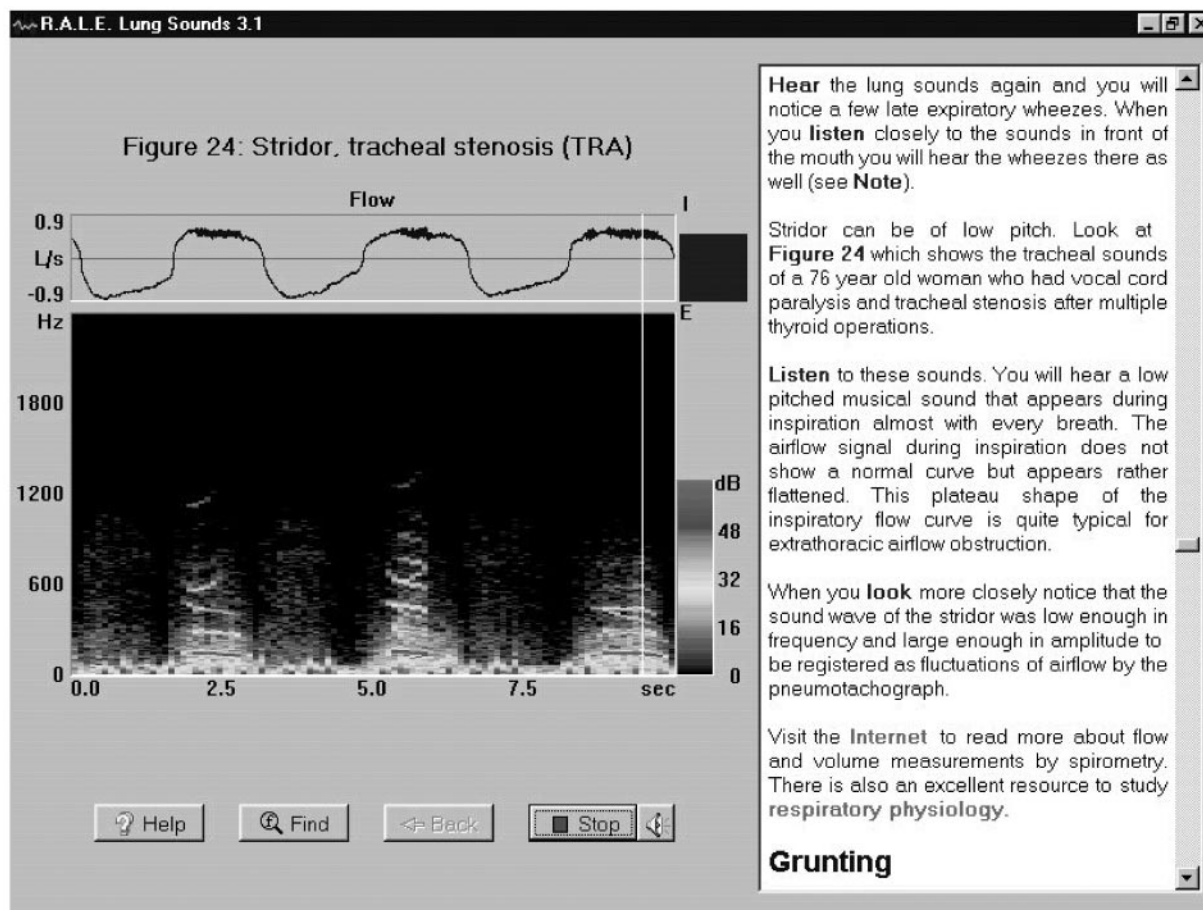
Sample of the teaching window in the R.A.L.E. Lung Sounds tutorial. This frame describes stridor. In the text box (right) the user can read content and click on hypertext-linked words. The white vertical line moves left to right in synchrony with the lung sound as it plays. In this graphic the line is nearing the end of inspiration of the last breath of a flow-versus-time curve. The sonogram (below the flow-versus-time curve) shows both the frequency and the loudness (in decibels [dB], with a color spectrum). Note that the stridor in this recording is predominately during inspiration. The solid bar on the upper right corner of the sonogram elevates and descends with inspiration and expiration. The navigation buttons (at the bottom of the graphics area) are "Help", "Find", "Back", "Stop", and the volume-control button (speaker symbol). (Courtesy of PixSoft.)
